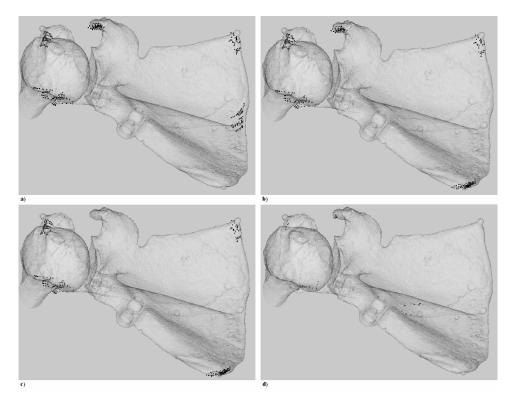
Points segmented from ultrasound images of different anatomical landmarks that were used in four registration experiments. a) to d) correspond to experiments 1 to 4. The 3D model is shown transparent to enhance visibility of the points segmented from the ultrasound images that were used for registration.
